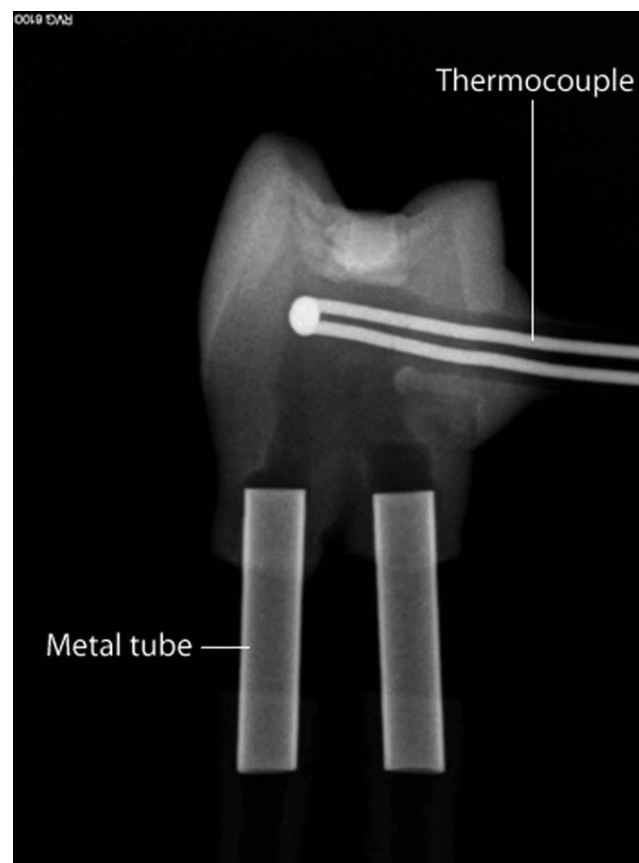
X-ray of the premolar with a thermocouple and metal tubes.
